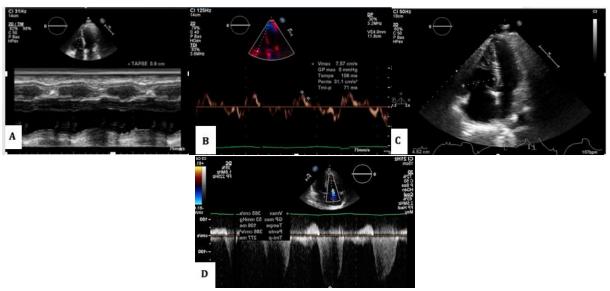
Transthoracic echocardiography showing a RV systolic dysfunction: TAPSE to 9mm (A), Tricuspid S wave at 7,5cm/s (B), RV dilatation, basal diameter at 41mm (C), and tricuspid insuffisancy giving a PAPS at 73mmhg (D)
